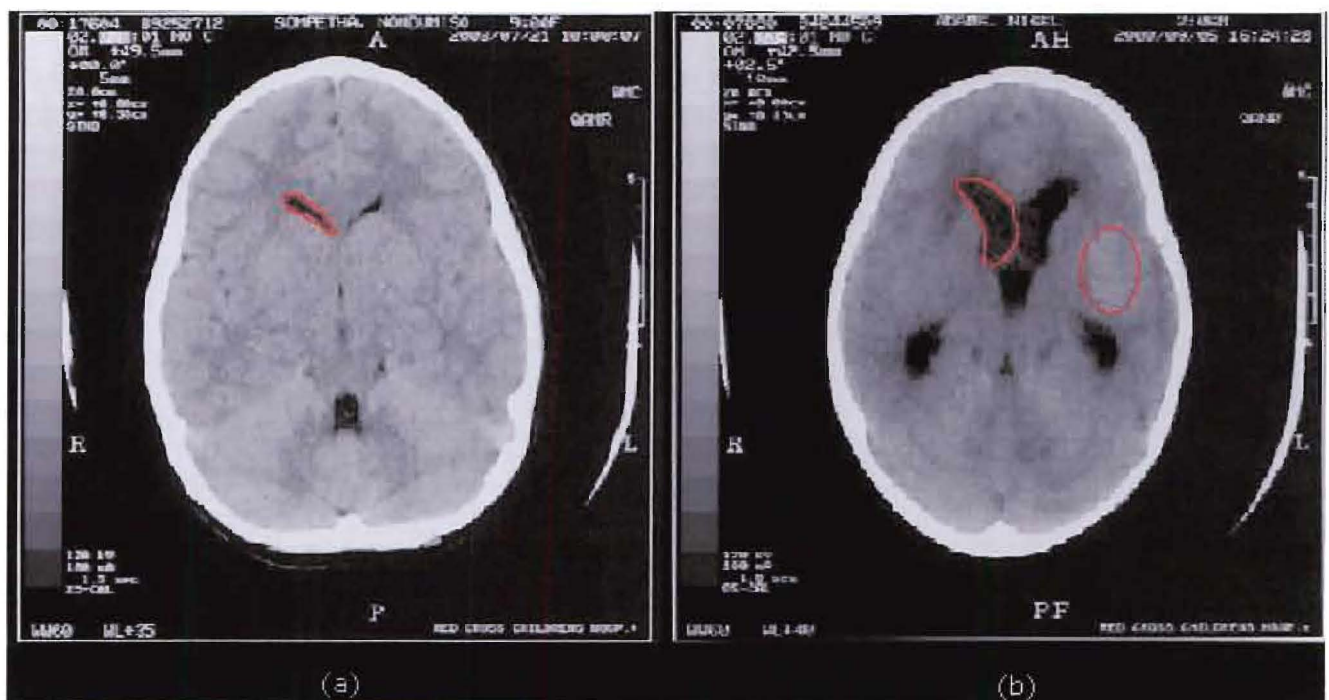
Showing CT scans from 2 different patients, (a) shows a normal brain scan. (b) shows clear signs of TBM. Note the large ventricle size and enhanced tissue in the oval area. Both images are taken from patients presenting at Red Cross Children's Hospital
